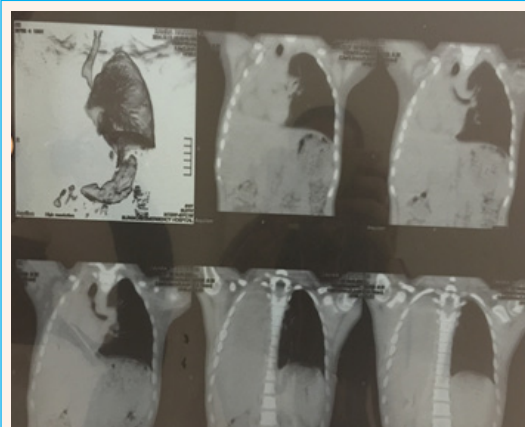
3 CT scan shows complete occlusion of the right main bronchus just below the carina.
